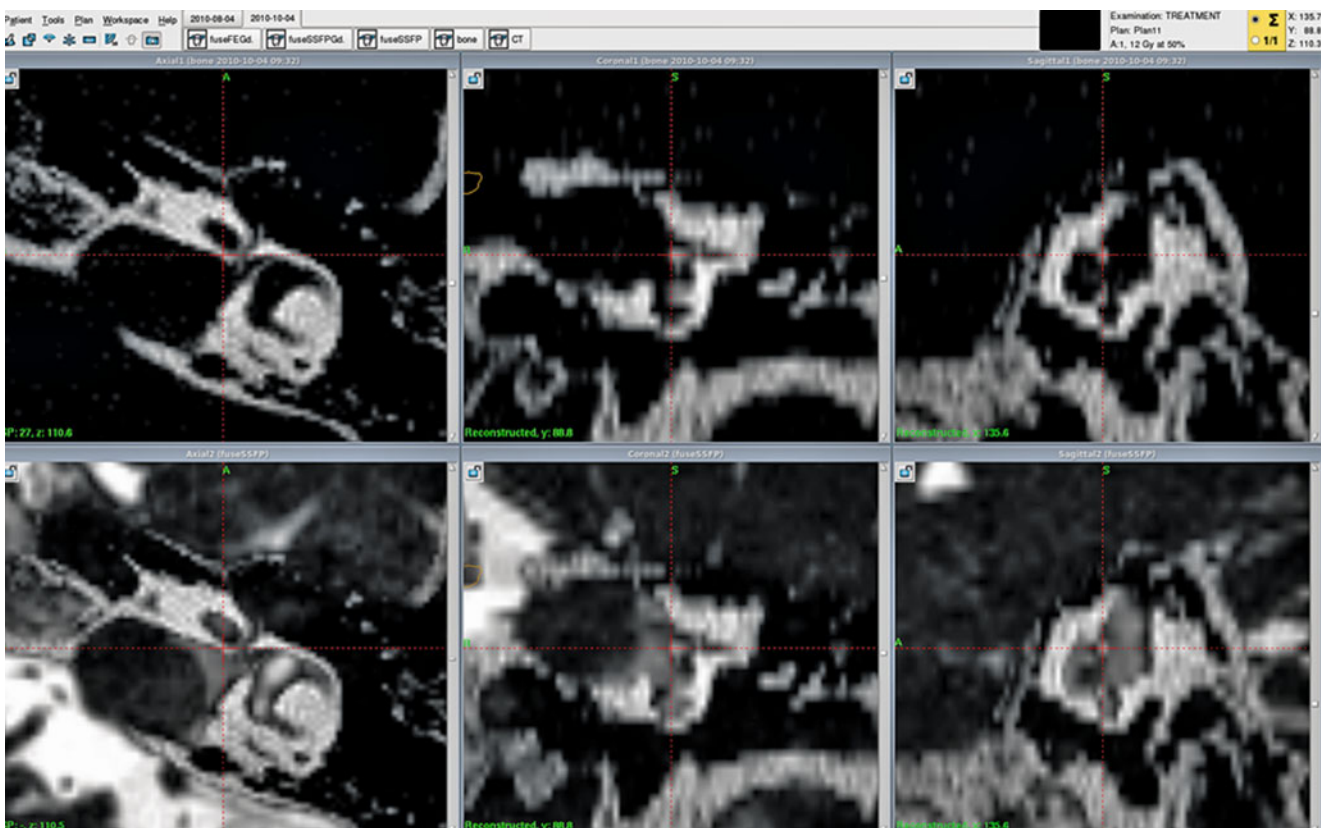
Left-sided vestibular schwannoma of Koos stage II. Identification of the intrameatal horizontal bar on “bone window” CT (*upper row*) and on its fusion with plain CISS images (*lower row*)
